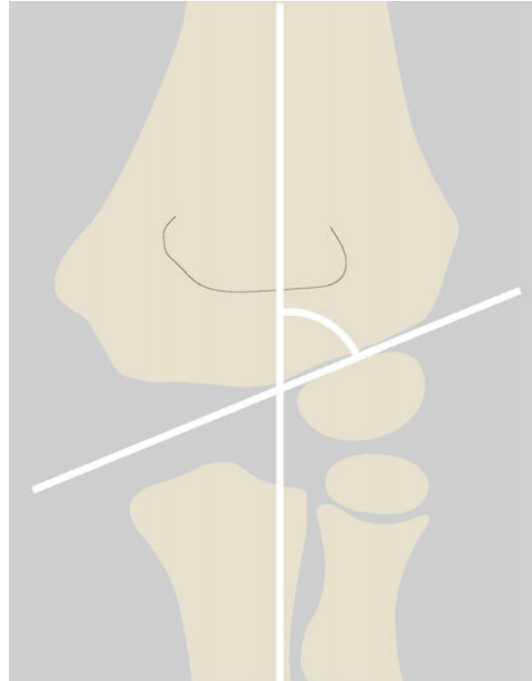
Technique of measuring the Baumann's angle from an anteroposterior radiograph
